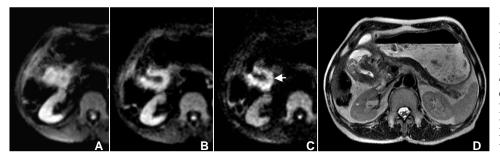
Gastric cancer of antrum. The signal of cancer and water in gastric lumen cannot be discriminated on low *b*-value DWI (Fig A), while it can be demonstrated clearly on high *b*-value DWI (Fig B).
